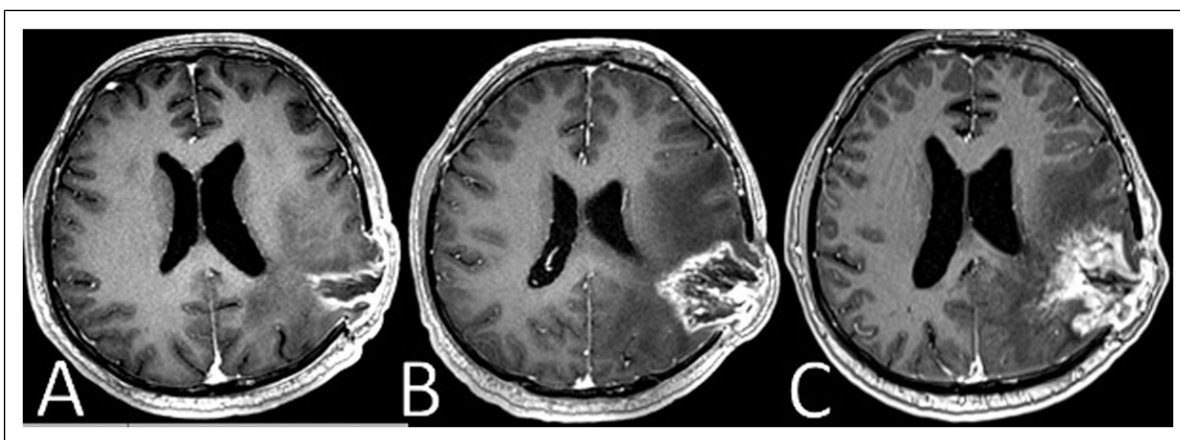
(a) Immediately after the second cranial surgery, the post-contrast axial T1-weighted image showed a peripherally reactive enhancing resection cavity. (b) At the 6-month follow-up after the start of immunotherapy, compared with the postoperative MRI, there is an increase in the size of the expansile enhancing lesion in the left temporal follow-up, regression in the interval process in the areas of increased perfusion adjacent to the left lateral ventricular wall compared with the previous examination, and a stable peripheral FLAIR signal. Taken together with the slight increase in size of the lateral peripheral enhancing nodular focus, the stability of the FLAIR signal, and the decrease in areas of high perfusion adjacent to the ventricle at the previous examination, this may be due to possible treatment-related fibrotic changes in the patient undergoing immunotherapy treatment, and close follow-up of this area will be useful. (c) In the left posterior temporal lobe, contrast enhancement increased and the lesion grew in the interim period, and there was growth of the mass component extending under the scalp on the left. The findings were evaluated in favor of tumor progression.
